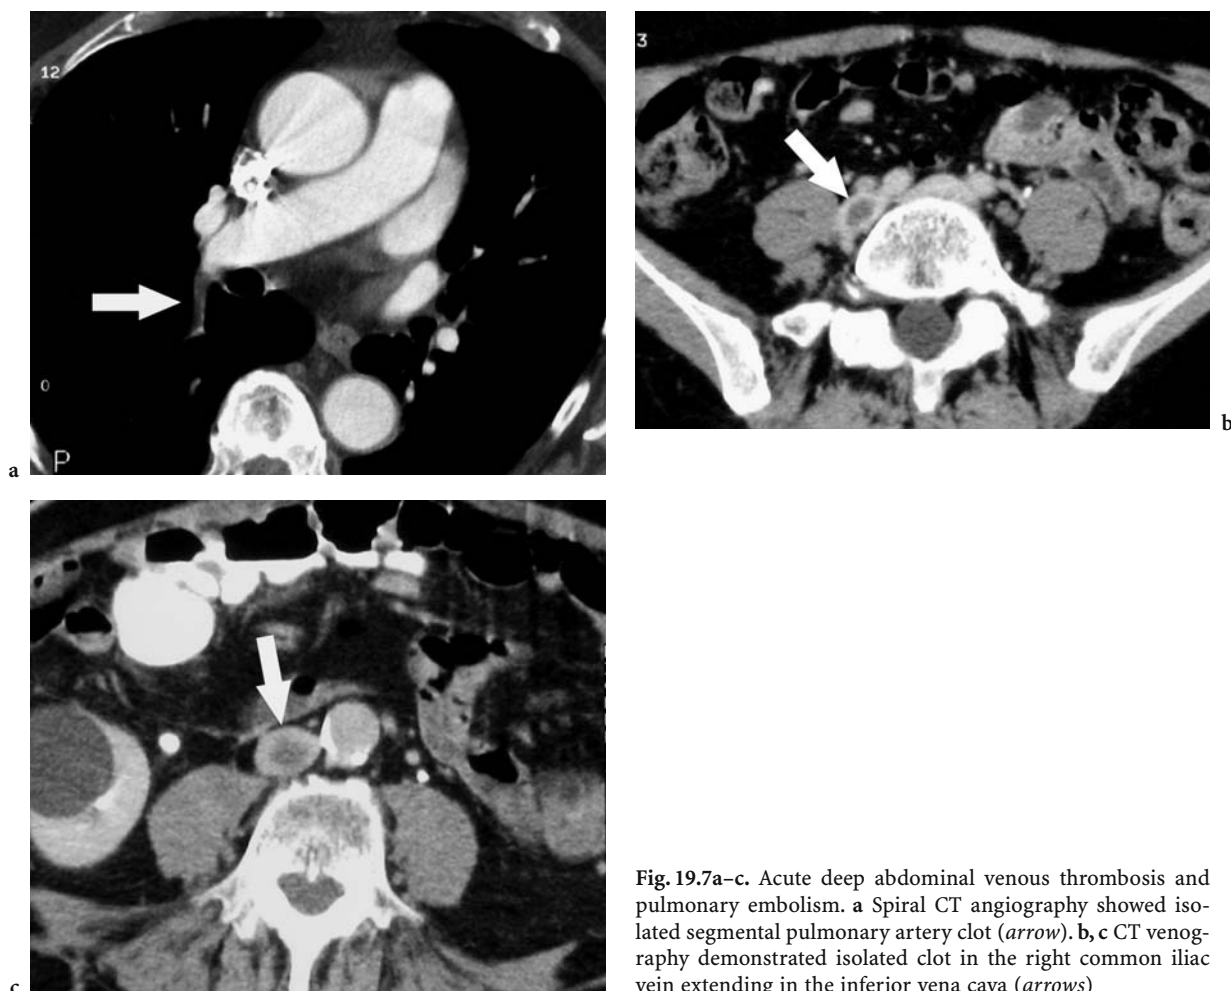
Acute deep abdominal venous thrombosis and pulmonary embolism. a Spiral CT angiography showed isolated segmental pulmonary artery clot (*arrow*). b, c CT venography demonstrated isolated clot in the right common iliac vein extending in the inferior vena cava (*arrows*)
